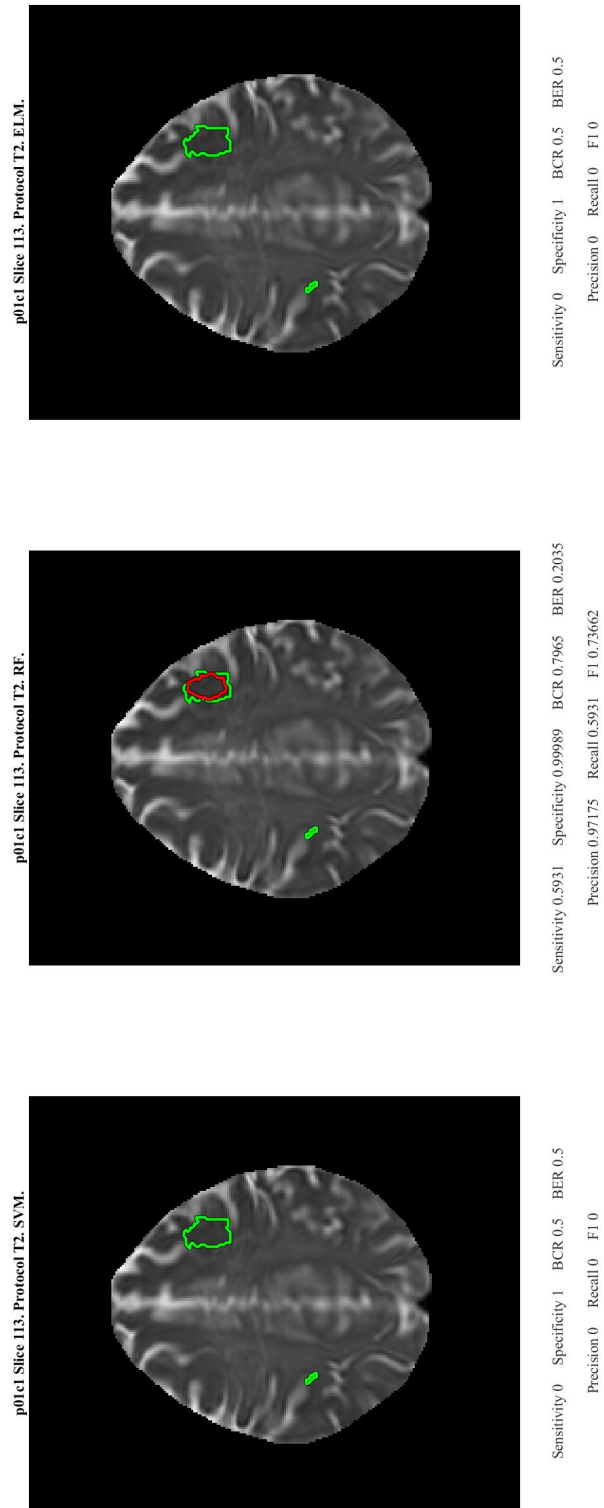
Multimodal sequence Segmented regions using all classifiers trained using only first-order statistics from Multimodal MRI sequences for unseen segmentation using dataset p01c1 T2 sequence on slice 113.
